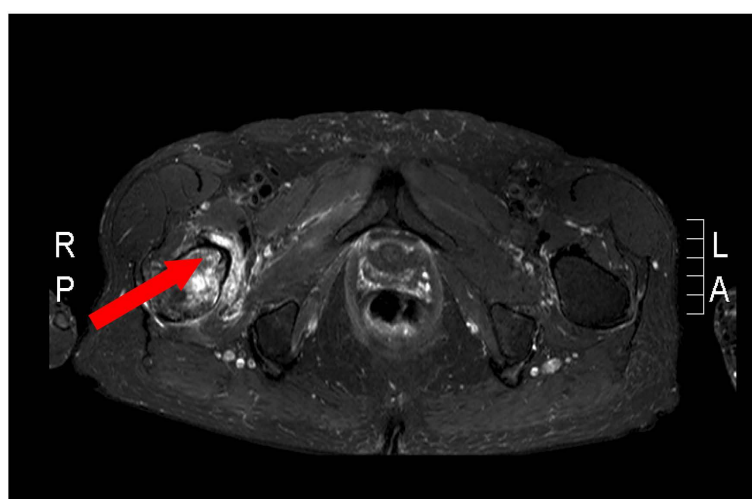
Follow-up MRI, one month later, T2 sequence.
